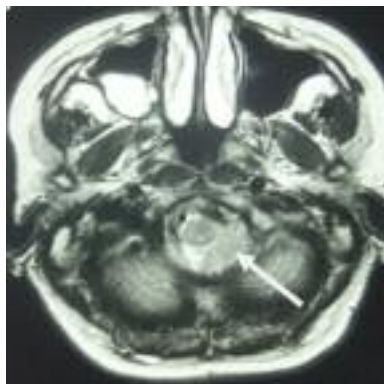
Preoperative axial T2 weighted MRI showing left cerebellar mega-tonsil (white arrow).
